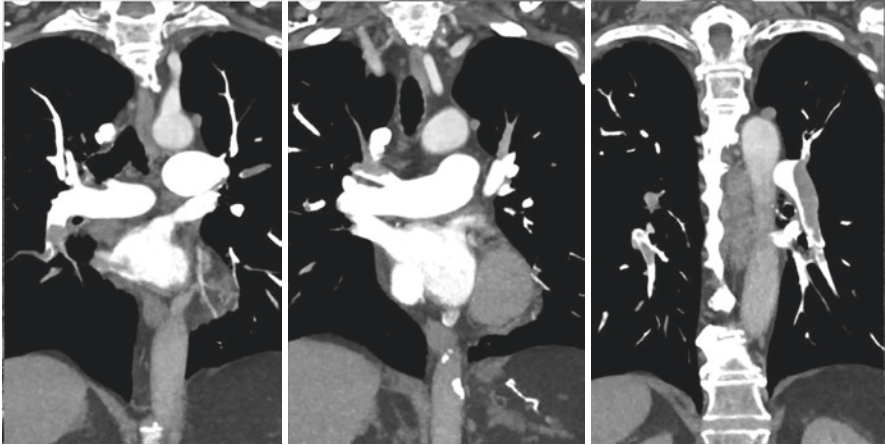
A female patient with massive PE. Chest computed tomography showing bilateral thrombus in the pulmonary circulation
